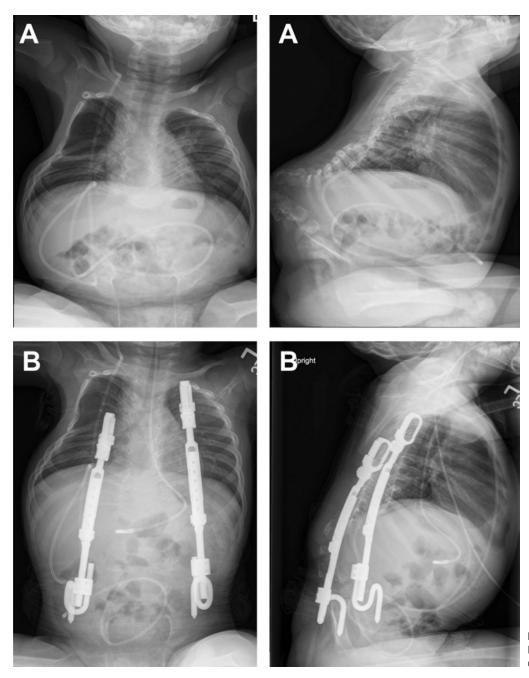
AP and Lateral Scoliosis Radiographs (A) Pre-VEPTR Insertion; (B) Post-VEPTR insertion in a child with a ventricular peritoneal shunt
